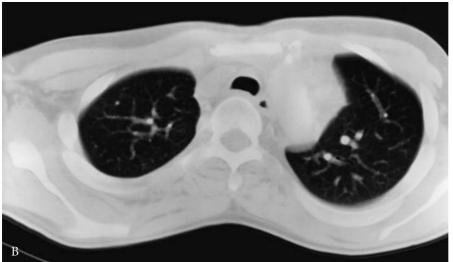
Postoperative computed tomography scans in the patient seen in Figure 15-22, showing a very adequate lumen in both the upper (A) and lower (B) trachea. Note the sternal alteration in A, compared with Figure 15-22A, and the thickened membranous wall of the trachea in B, compared with Figure 15-22B.
